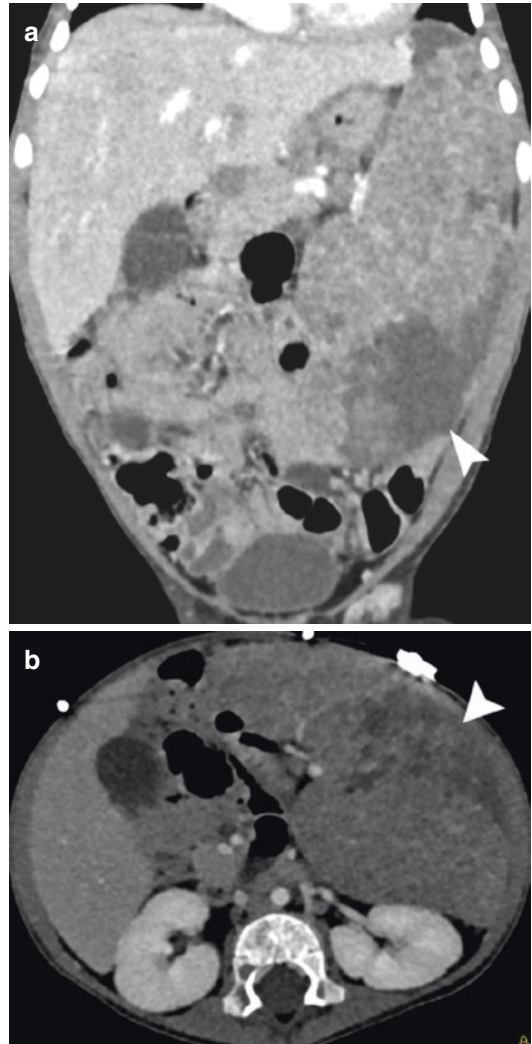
Two-year-old girl with left abdominal pain. Bone lesions had been diagnosed previously. (a) Coronal CT image. (b) Axial CE-CT showing massive splenomegaly with heterogeneous enhancement corresponding to splenic infarction (arrowhead). Diagnosis of LCH was made on bone biopsy
